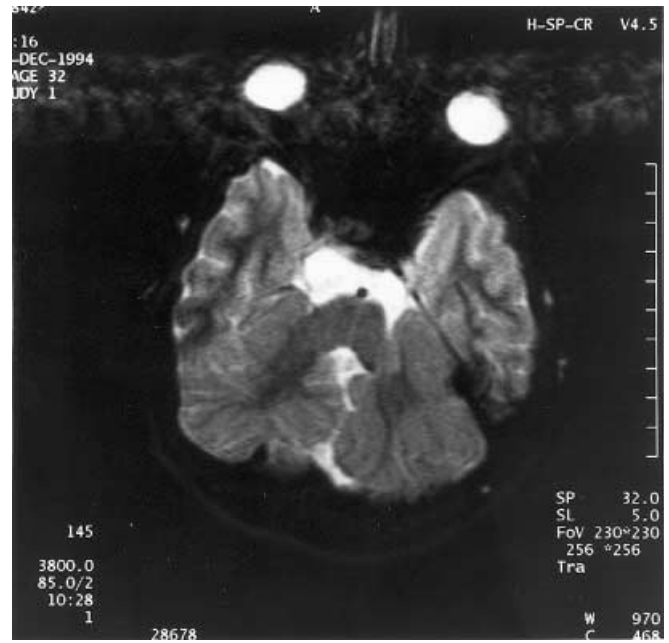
a, b. Axial and coronal T2-weighted images show cyst-like inclusions in the hemispheres and vermis (*arrowheads*). Note abnormal foliation of anterior lobe of vermis in b (*arrow*)
